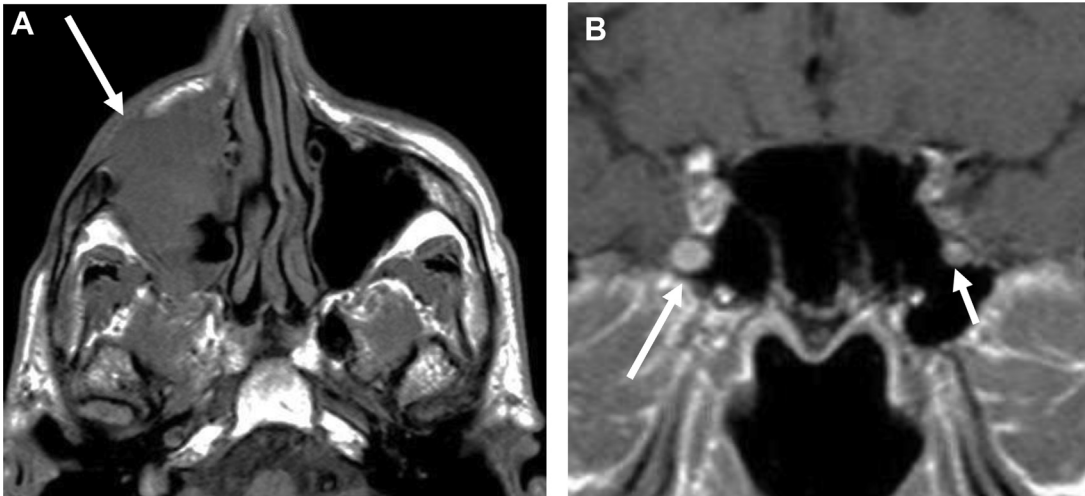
MR imaging of perineural spread. (A) Axial noncontrast T1WI shows a large right maxillary sinus carcinoma (arrow). (B) Coronal contrast-enhanced T1WI shows diffuse enlargement and enhancement of the maxillary division of the trigeminal nerve (V2) indicative of retrograde perineural spread (large arrow). Compare this with the normal appearance of V2 on the contralateral site (short arrow).
